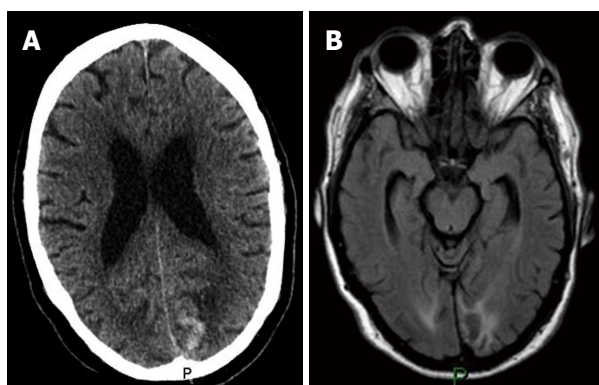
Neurological imaging. A: Unenhanced computer tomography brain examination (axial view) demonstrating left occipital high attenuation with surrounding low attenuation; B: Magnetic resonance imaging brain examination (axial view, FLAIR sequence) demonstrating left occipital lobe infarct with haemorrhagic transformation.
